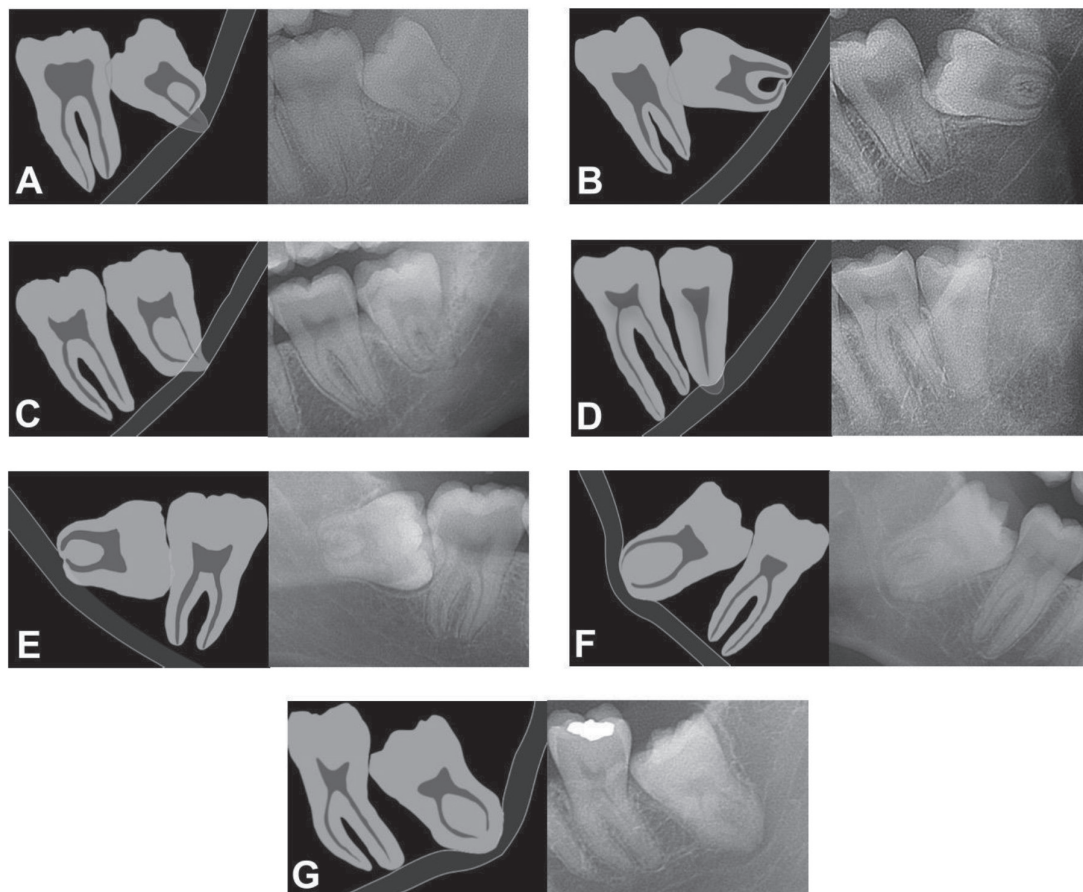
Panoramic radiographic signs of nerve involvement. (A) Darkening of root, (B) Deflection of root, (C) Narrowing of root, (D) Dark and bifid apex of root, (E) Interruption of white line, (F) Diversion of canal, (G) Narrowing of canal.
